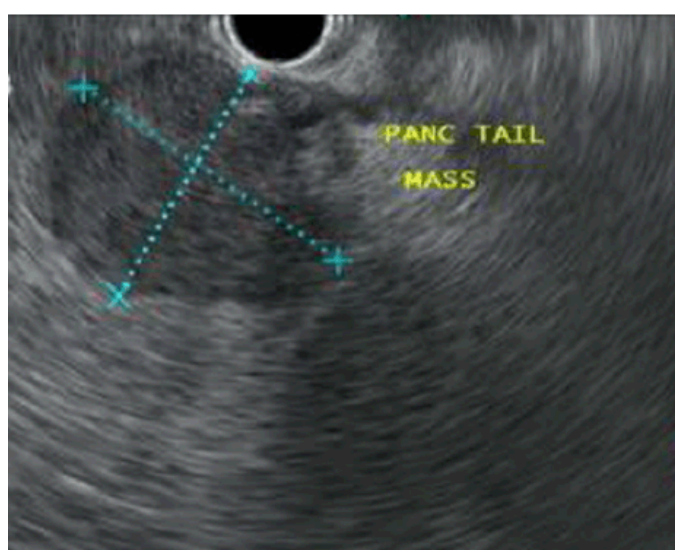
Endoscopic Ultrasound showing 3.3x2.7 cm hypoechoic mass on the tail of the pancreas extending towards the splenic hilum.
